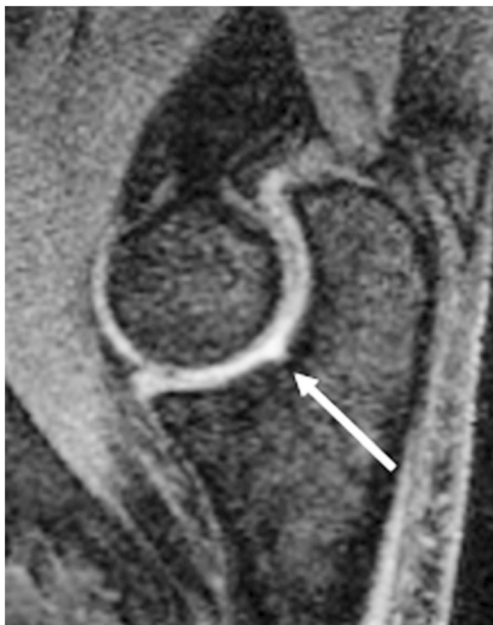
Pseudodefekt of the capitellum. Sagittal T2-weighted fat-suppressed MR image of the elbow in a 14-year-old girl. Pseudodefekt (*arrow*) represents the normal posterior tapering of the capitellum at its posterolateral margin. This should not be mistaken for an osteochondral lesion
